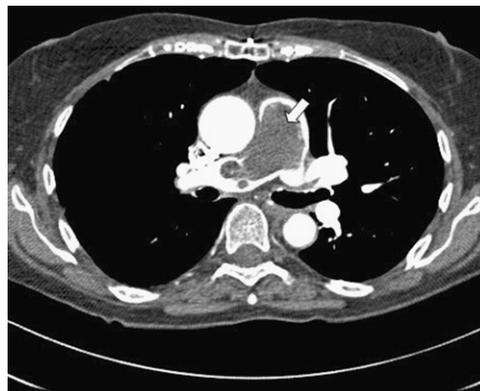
Computed tomography angiogram demonstrating large mass nearly occluding the main pulmonary artery (*arrow*) and extending into the right and left pulmonary arteries representing a pulmonary artery sarcoma.
